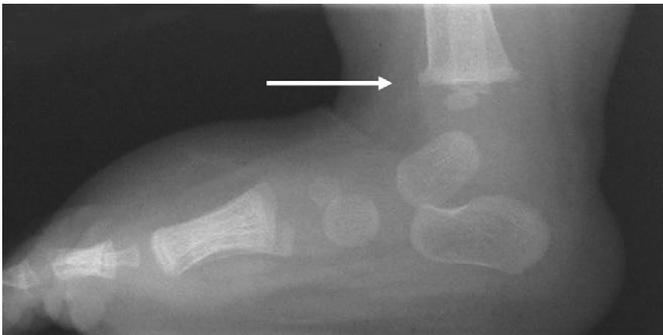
Corner fracture. Radiograph of a distal tibia corner fracture. The classic metaphyseal-epiphyseal injury can be seen clearly in this radiograph.
